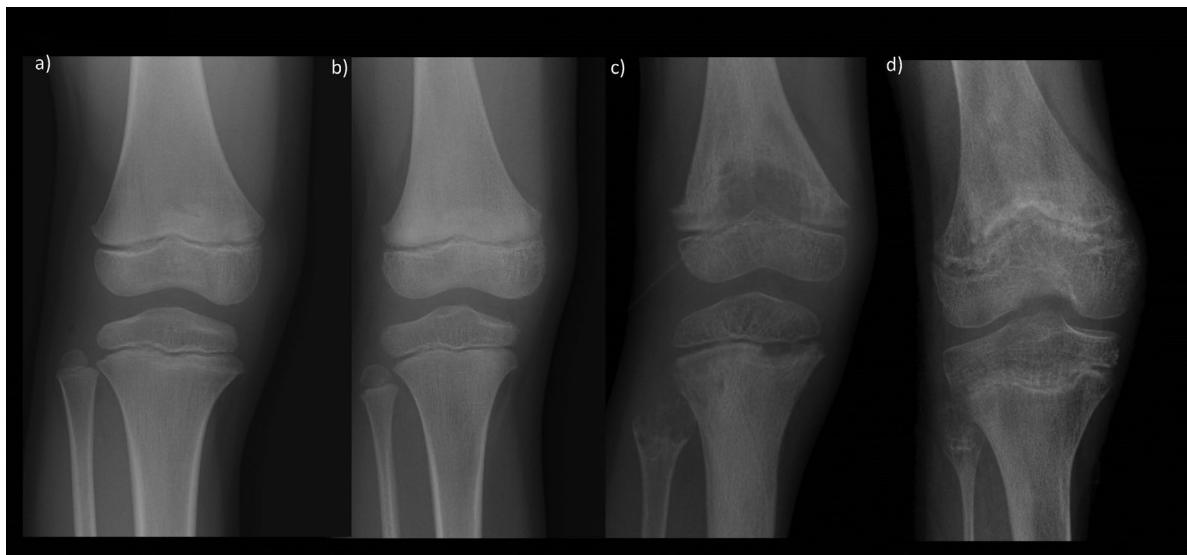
Radiographic severity of HPP in children: Anteroposterior view of the right knee of the patients shown in the videos. Note no abnormalities in odonto HPP (A), subtle changes observed here best in the head of the fibula in mild childhood HPP (B), characteristic “tongues of radiolucency” and metaphyseal changes in severe childhood HPP (C), and especially marked findings in the survivor of infantile HPP (D).
